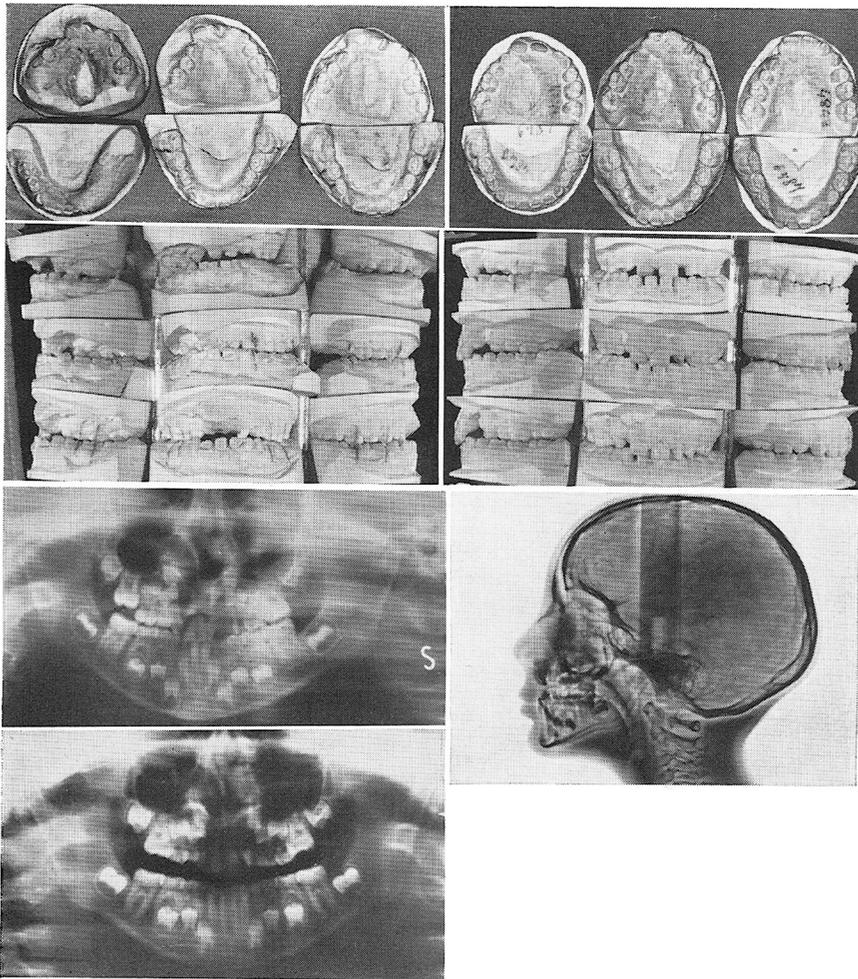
Unilateral right cleft lip and palate, with crossbite and underdevelopment of the maxilla, which are evident in the profile radiograph. Orthodontic treatment was begun at the age of 6 years in order to obtain a sagittal and transversal maxillary expansion and terminated in a normal occlusion (lower right). Panoramic radiographs were performed at the beginning of the orthodontic treatment and again after two years. From those films, it is possible to compare the maxillary growth and the development of the permanent dental buds at the margins of the cleft. The width of the cleft appears reduced. Plaster models were made at the ages of 2 years, 6 years, and then annually during the treatment (from top left to bottom right).
